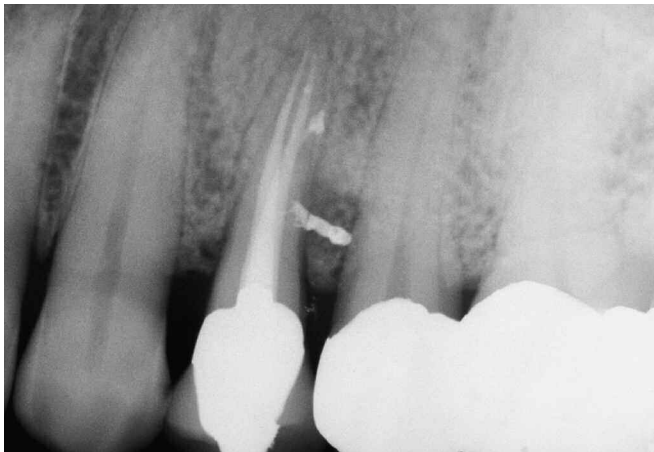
A 10-year recall radiograph shows healing.*
